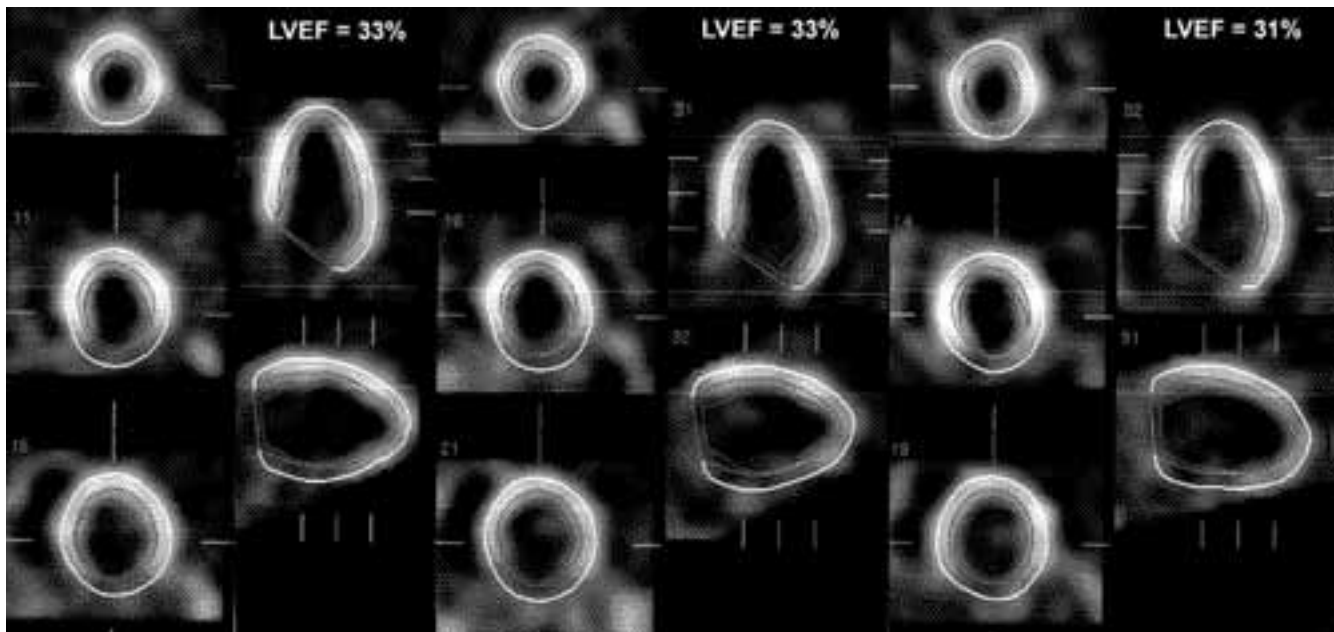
Gated SPECT studies of a patient with coronary artery disease and LV dysfunction. From left to right: short axis slices, midventricular horizontal (top) and vertical (bottom) long axis slices of the prevascularization nitrate-enhanced baseline study (columns 1 and 2); corresponding slices of the low-dose dobutamine study (columns 3 and 4) and of the postvascularization follow-up study (columns 5 and 6). The absence of changes in regional wall motion and LVEF during inotropic stimulation predicts the lack of improvement after revascularization.
